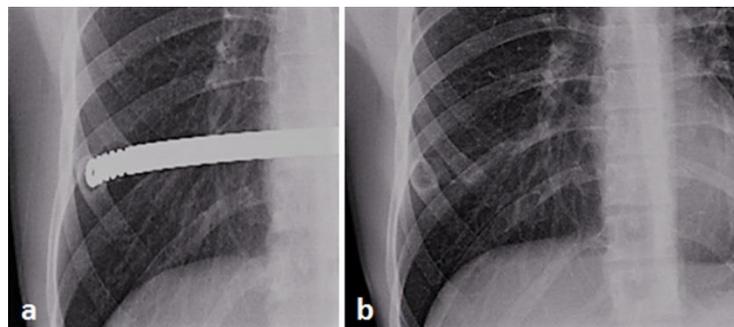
Image of the ossification on posteroanterior chest x-ray (a: preoperatif, b: postoperatif)
